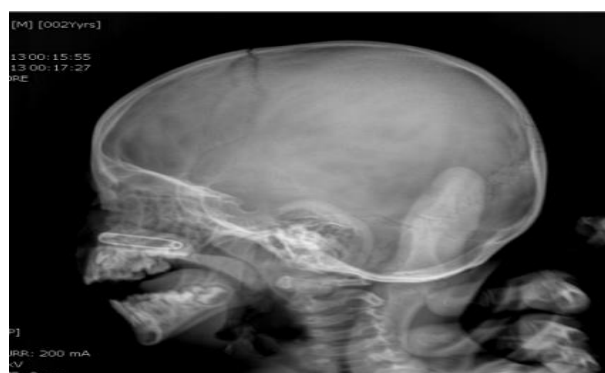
X-ray safety pin.
